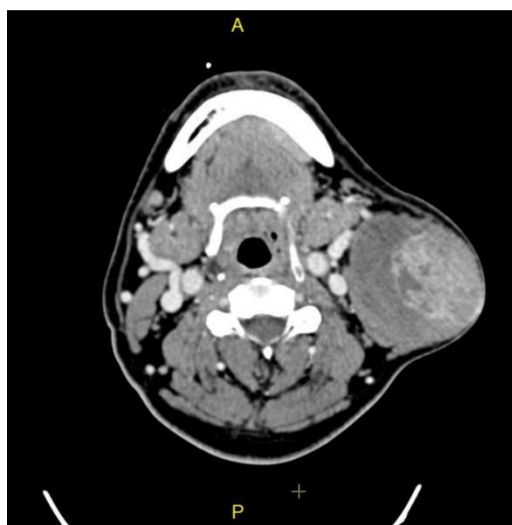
CT scan of the neck with contrast of the patient demonstrating large left parotid solid cystic mass in axial view
